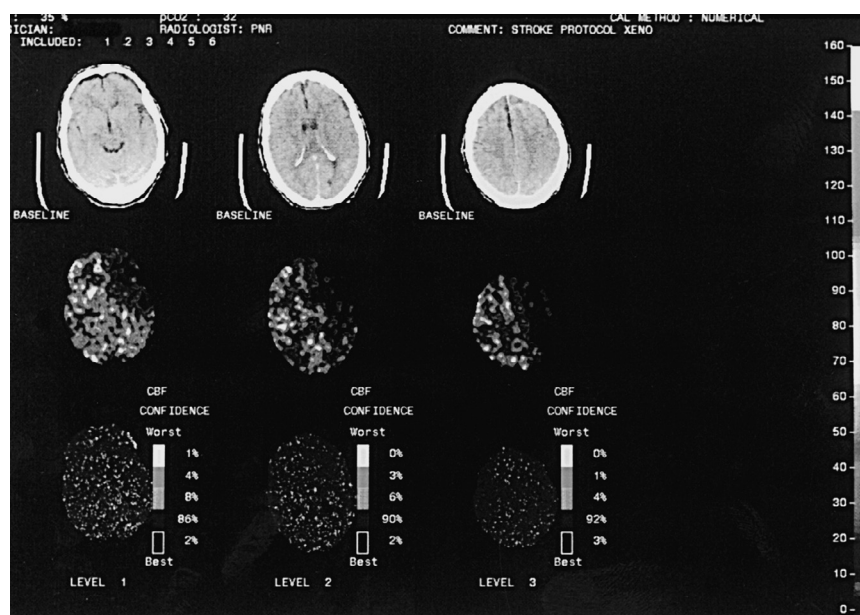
■ Xenon computed tomography blood flow study from a patient with a large left hemisphere stroke 3 hours after onset of symptoms. Flow is nearly absent throughout the middle cerebral artery territory on the left.
